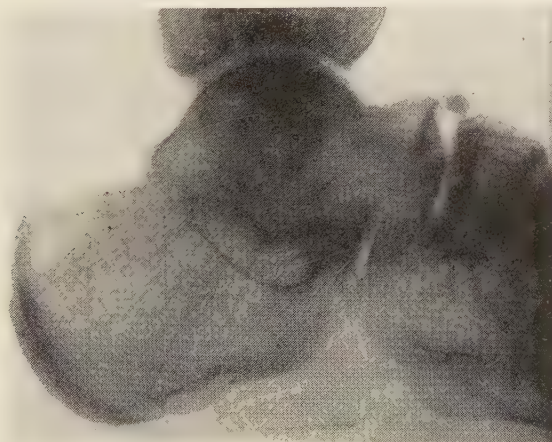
Female, aged 21. Only right foot radiographed. (BBH).
